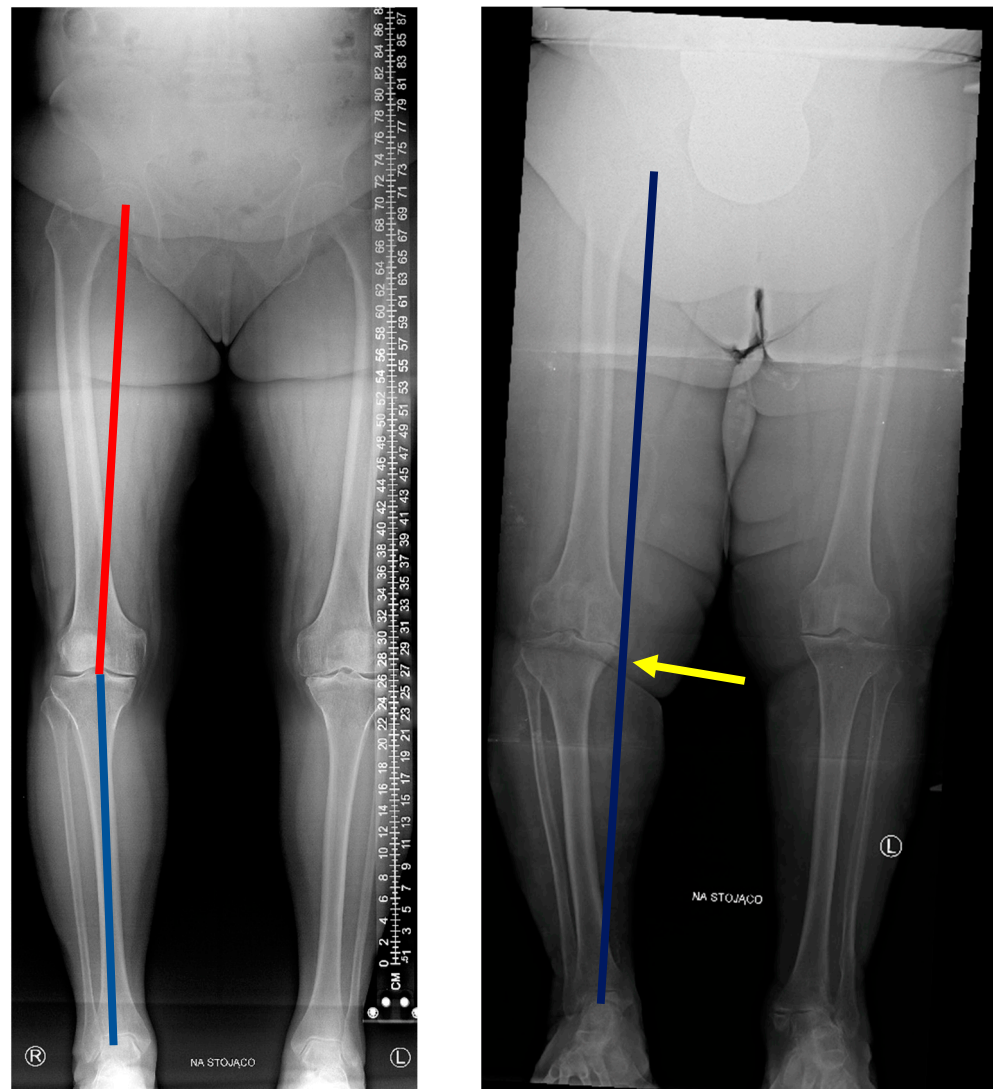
Measurement X-ray of the lower limbs in a patient with a slight varus deformity of the knee joint (left) and an advanced deformity (right). On the left, HKA angle is presented: red line shows hip–knee line; blue line shows knee–ankle line. On the right: narrowing of the medial compartment (yellow arrow) affecting the mechanical axis of the limb (blue line). The line moved medially indicates varus deformity of the knee joint. Source: proprietary material (description “na stojąco” [pl] means in the weightbearing position).
